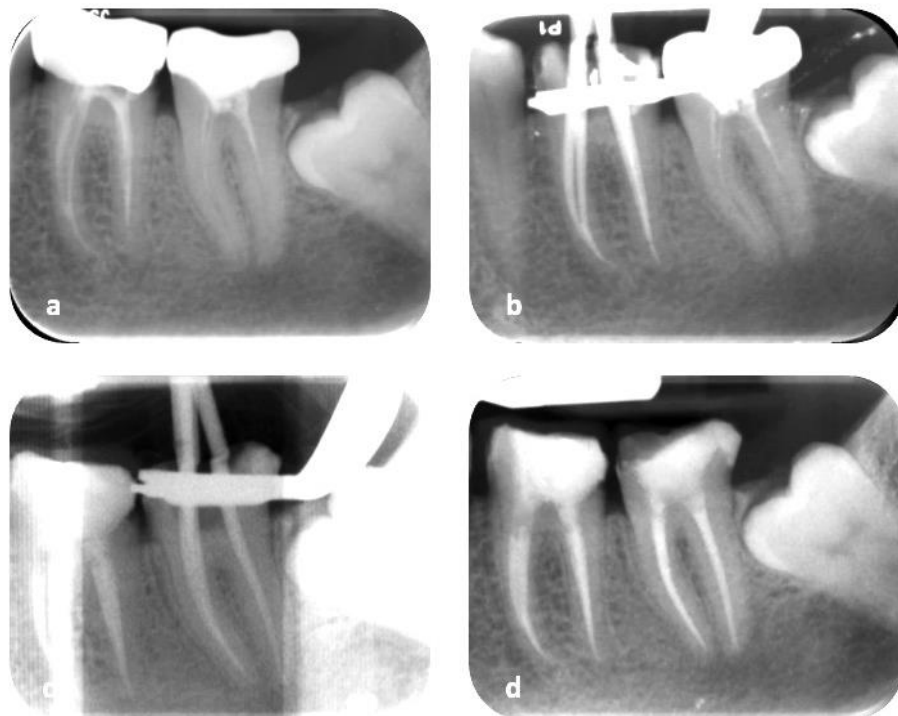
PA radiographs of tooth 36 and 37 (a) Pre-operative (b) Master cone 36 (c) Master cone 37, (d) Postoperative.
